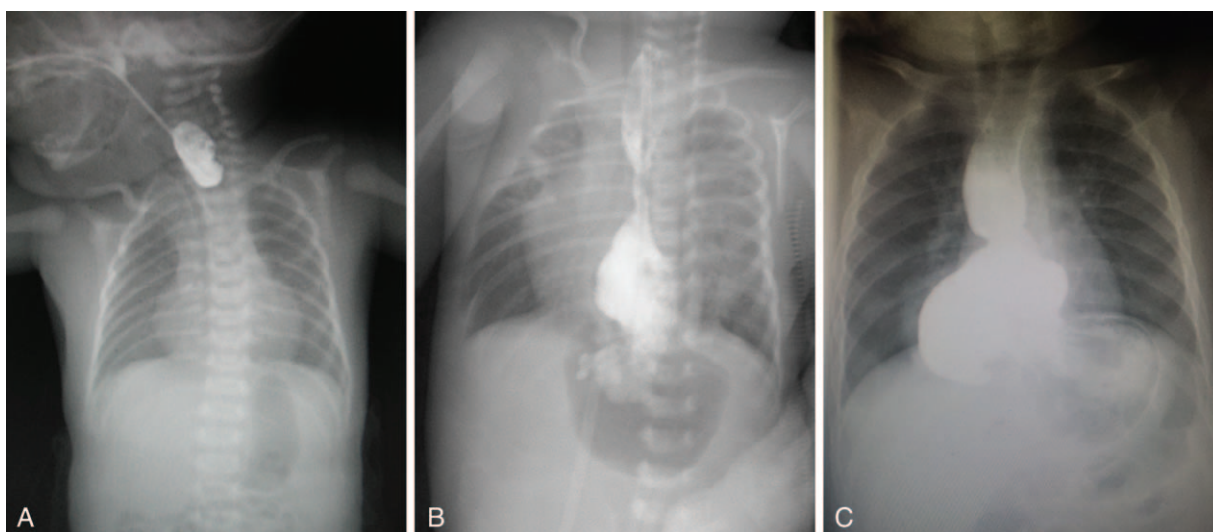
Results of radiography before the surgery and at 2 months and 1-year post-operatively of case number 9, respectively. (A) Radiography before the surgery. (B) Radiography at 2 months after the surgery. (C) Radiography at 1 year postoperatively.
